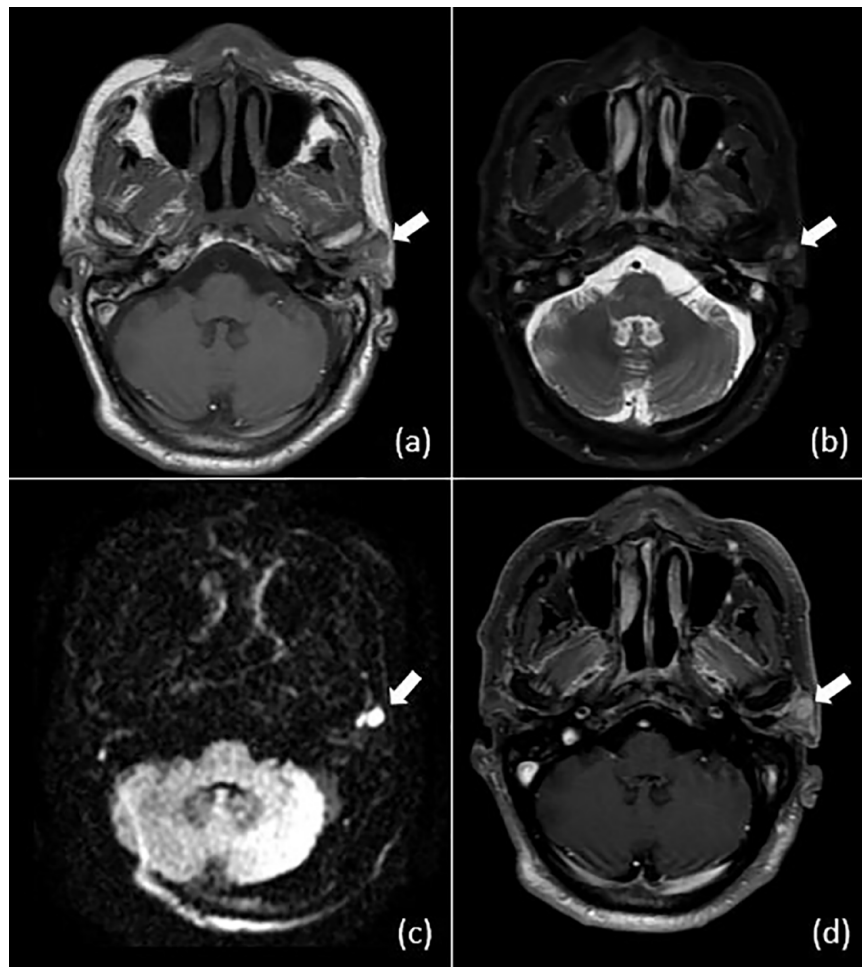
An axial section passing through the base of the skull of a patient undergoing treatment for nasopharyngeal carcinoma, showcasing various imaging sequences: T1 fast spin-echo (a), T2-weighted (b) with fat signal saturation, diffusion-weighted imaging (c), and T1-weighted with fat saturation post-gadolinium injection (d).
